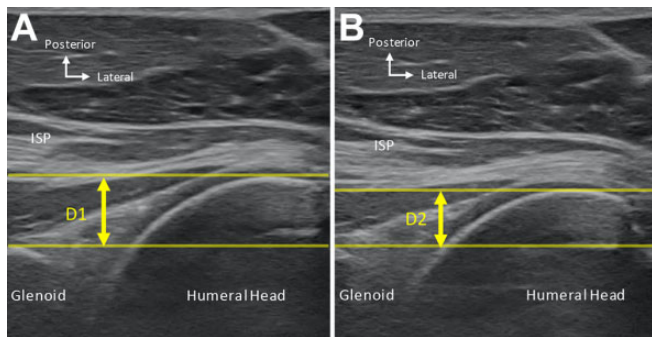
Ultrasound assessment of anterior translation in the glenohumeral joint. Two parallel lines (yellow straight lines) are drawn through the posterior edges of the glenoid and the humeral head shown in panels A and B. D1 and D2 are the shortest distances measured between the 2 parallel lines (vertical yellow lines with arrows) (A) without the 40-N distraction force and (B) with it toward the humeral head, respectively. The difference between D1 and D2 was calculated as the anterior translation. ISP, infraspinatus tendon.
